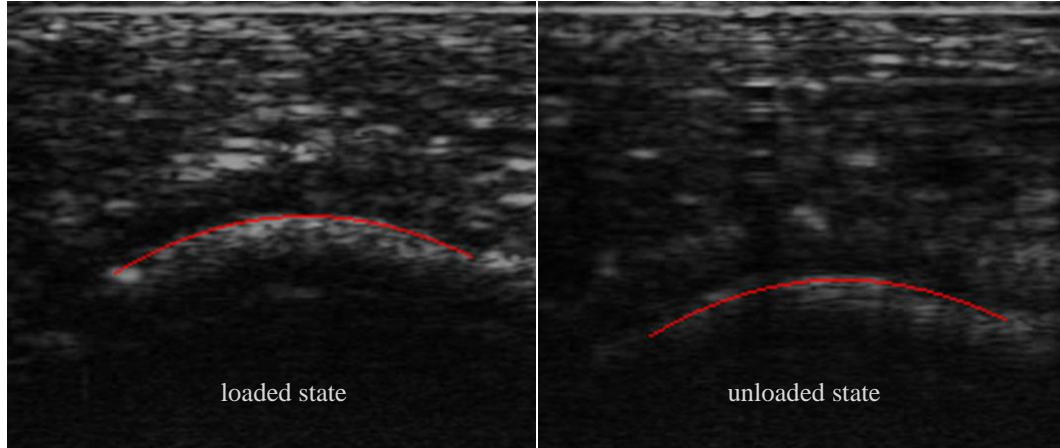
Tracking the calcaneus position with in-house Matlab software during ultrasound tests.
